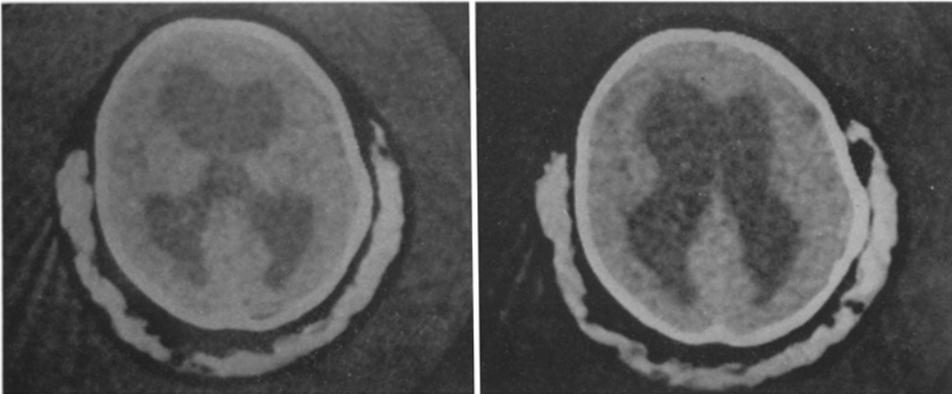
CT scan of the patient, showing remarkable enlargement of the lateral and 3rd ventricles.
